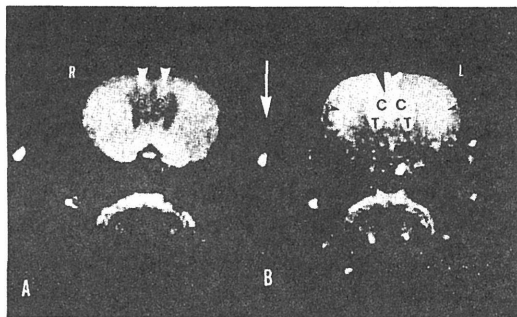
照射後 5 ヶ月経過時のラット頭部 MRI 冠状断を示す。(spin echo 法, Tr/Te=500/30 ms, 2 mm 幅)。単純では側脳室の拡大 (小矢頭) と脳梁 (cc) を中心に低信号域 (大矢頭) を認め (A), Gd-DTPA による造影では単純 MRI にて低信号を呈した部分が造影効果を示し、また視床核 (T) にも造影効果が見られる。外包にも淡い造影効果が見られる (黒矢頭)。皮質部には異常信号を認めない (B)。図中央の矢印は照射の方向と深度 (頭皮より 5 mm) を示す。
